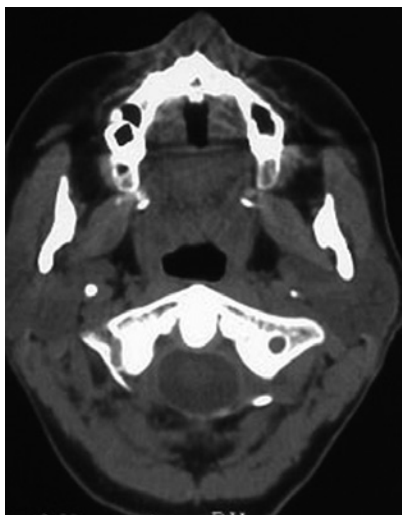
CT overview over the trans-sinus BOI implants in the posterior maxilla
